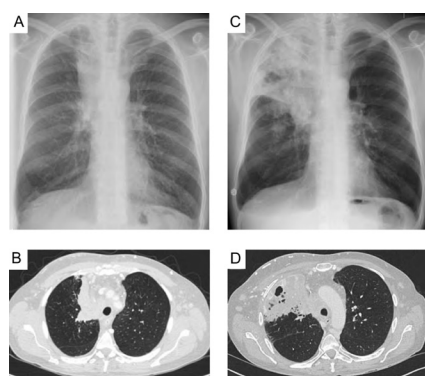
Development of pulmonary TB. Chest X-ray at start of triplet therapy shows right upper lobe apical tumour (A), while 56 days later extensive right upper lobe consolidation has developed (C). Comparison of diagnostic CT scan performed 2 weeks before initial chest X-ray (B) with the CT scan on readmission shows response of the tumour to triplet therapy but new consolidation with cavitation (D).
